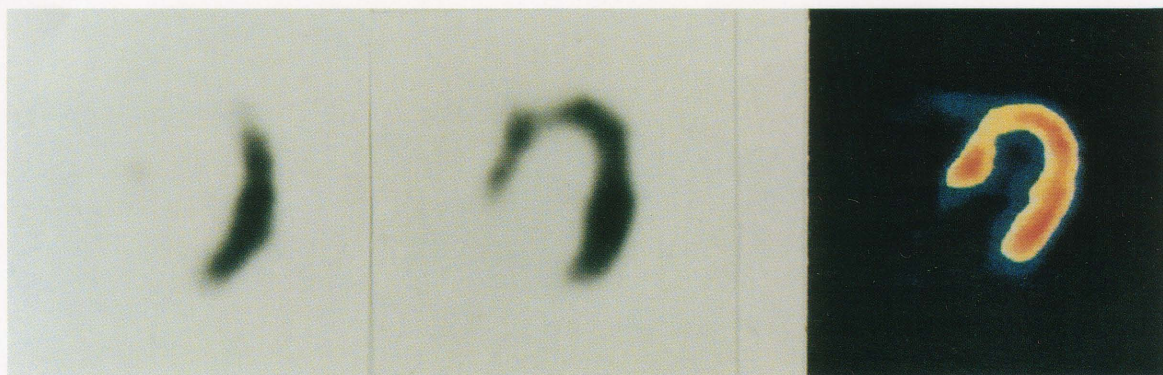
A case with anterior myocardial infarction with effort angina. Left panel: ^{201}Tl stress image; middle panel: ^{201}Tl reinjection image; right panel: ^{18}F FDG-PET image.
